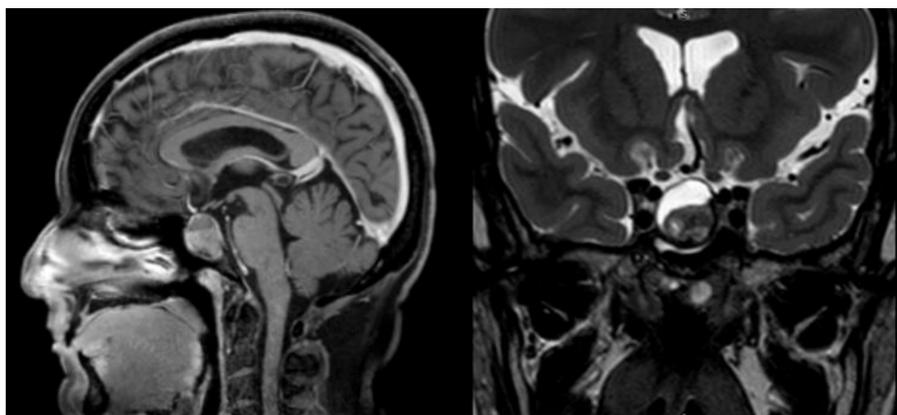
Second case - Magnetic resonance imaging of patient 2 showing in sagittal (A) and coronal (B) views a moderately sized solid-cystic lesion with fluid level, mild mass effect, and heterogeneous contrast enhancement.
